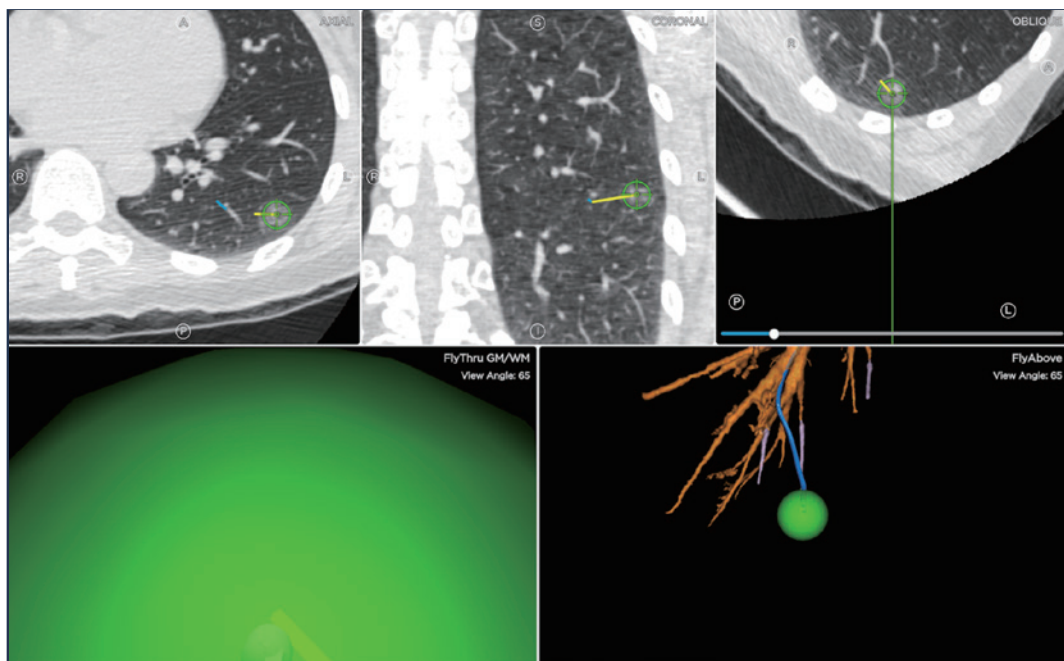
Example of Electromagnetic navigation. (Top three panels) The green target represents the site corresponding to the planned target on the CT scan. The blue line indicates the identified airway leading close to the target, while the yellow line shows the straight path from the end of the airway to the target. (Bottom panel) Intraoperatively, when the sensor-enabled tool reaches the pre-planned site, the target indicator turns green, signifying a suitable location for sampling. (Personal collection)
